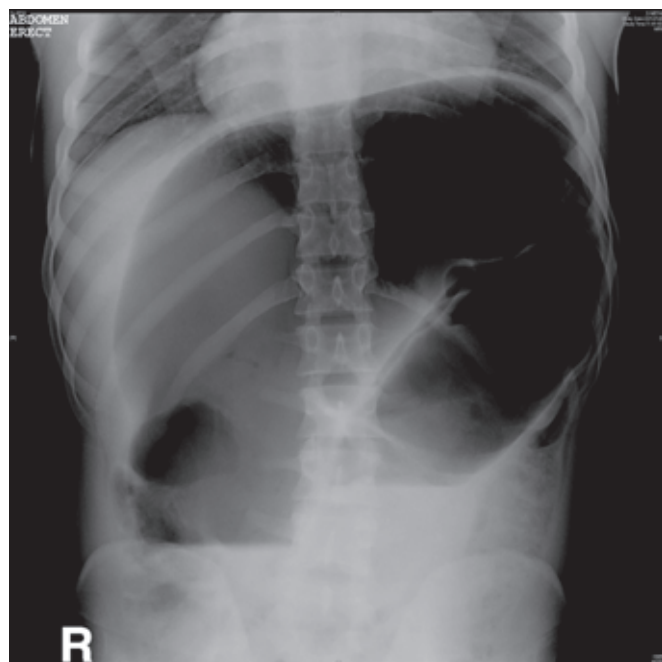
X-ray of abdomen showing volvulus (case 1)
